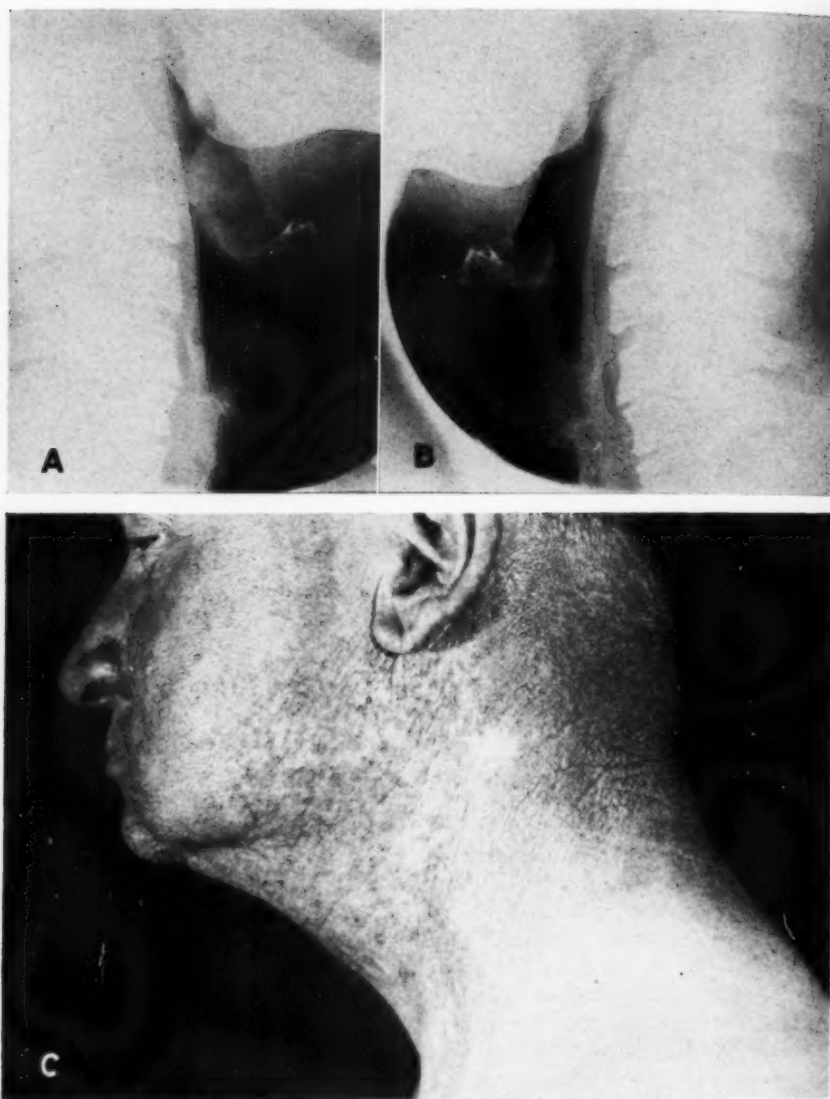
A. Large anaplastic epidermoid carcinoma, left base of tongue, completely obliterating vallecula, as seen in lateral roentgenogram. Palpable lymph node 3 cm. in diameter at angle of mandible on left; 2 cm. in diameter on right. B. Restitution of vallecular space and normal contour of base of tongue following irradiation.
